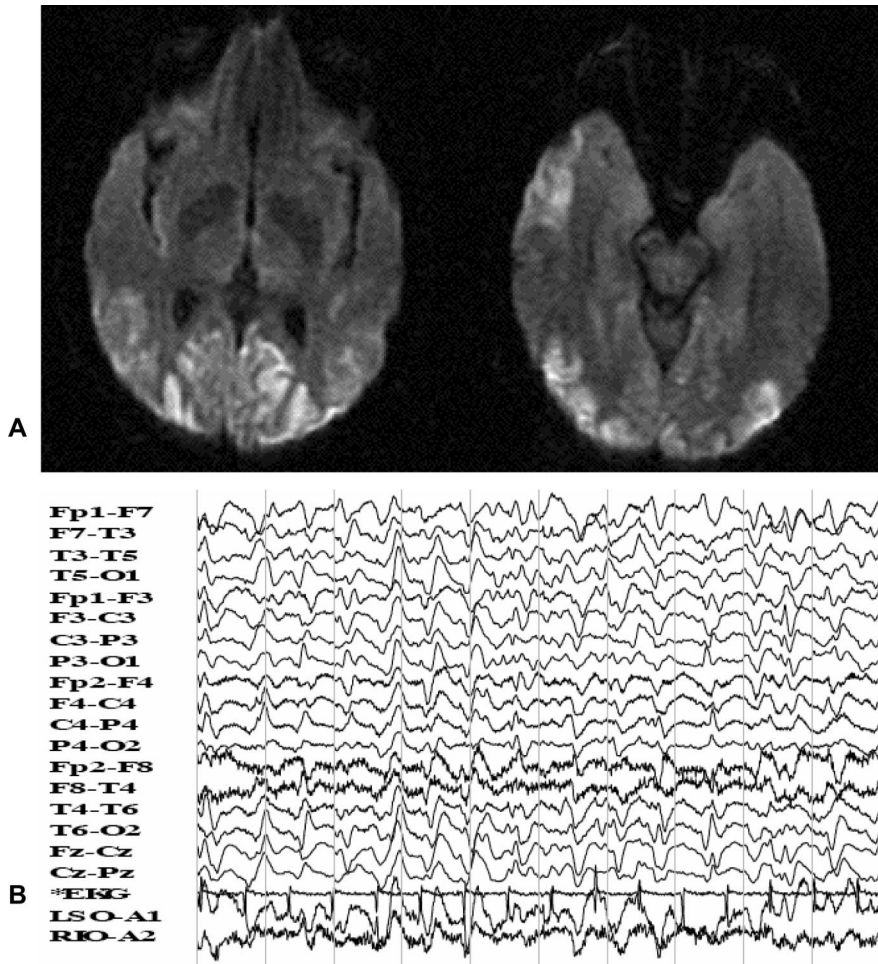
(A) Diffusion-weighted MRI (DWI) showing ribbon-shaped hyperintense signals in the occipital and right temporal lobes. DWI is valuable for diagnosis of Creutzfeldt–Jakob disease.² DWI is more tolerant of motion artifacts than T2WI and fluid attenuated inversion recovery images, making it superior in patients with myoclonic jerks. Similar DWI changes can be seen in anoxia, reversible posterior leukoencephalopathy syndrome, and CNS vasculitis. The basal ganglia are spared. (B) EEG revealing runs of bihemispheric, periodic sharp wave complexes.
